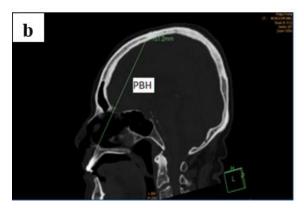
CT image showing the PBH
